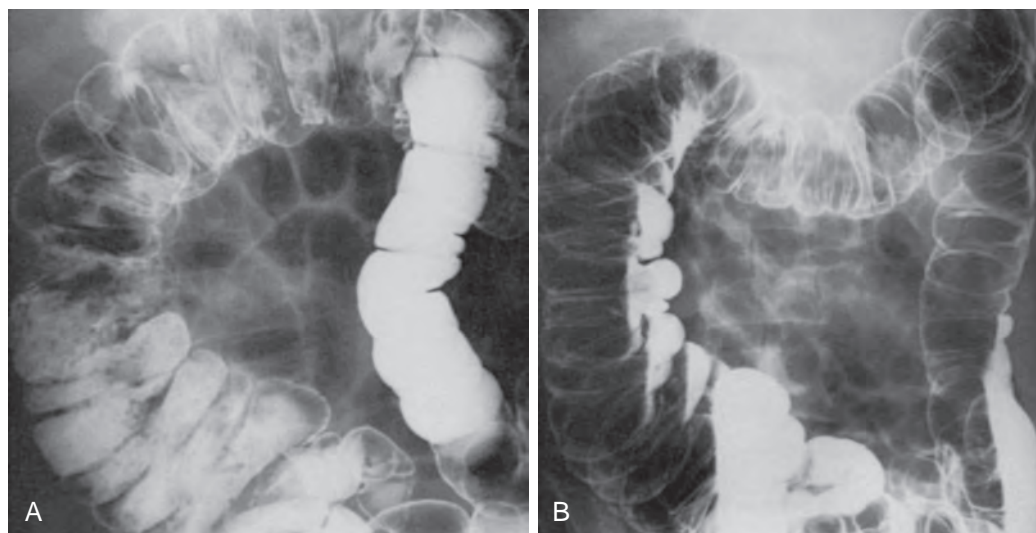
Importance of the decubitus view with imperfect bowel preparation. A. Oblique view shows considerable fecal residue in the right colon. B. Left lateral decubitus overhead radiograph shows fecal debris layering out in the barium, enabling a clear view of most of the right colon.
